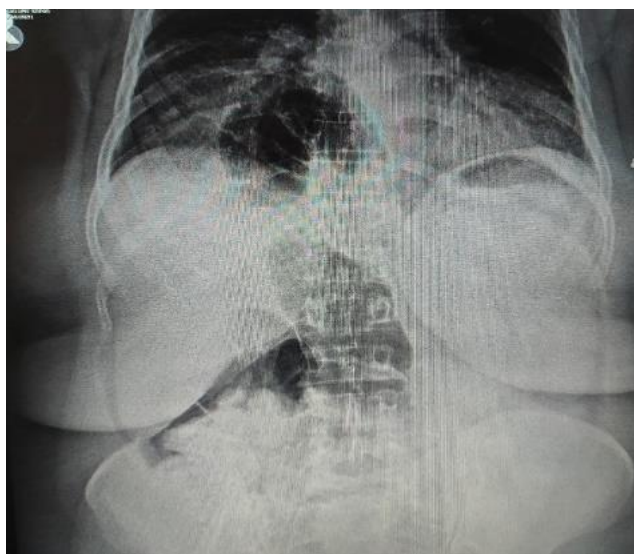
Standing abdomen X-Ray; Air-fluid levels
